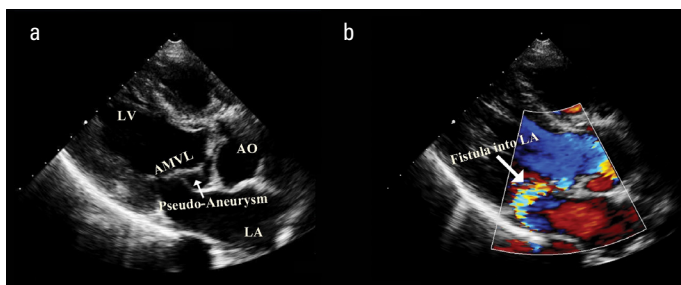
a-b. (a) Two-dimensional echocardiography of MAIVF pseudoaneurysm. (b) Eccentric turbulent flow secondary to fistulization into the left atrium.
